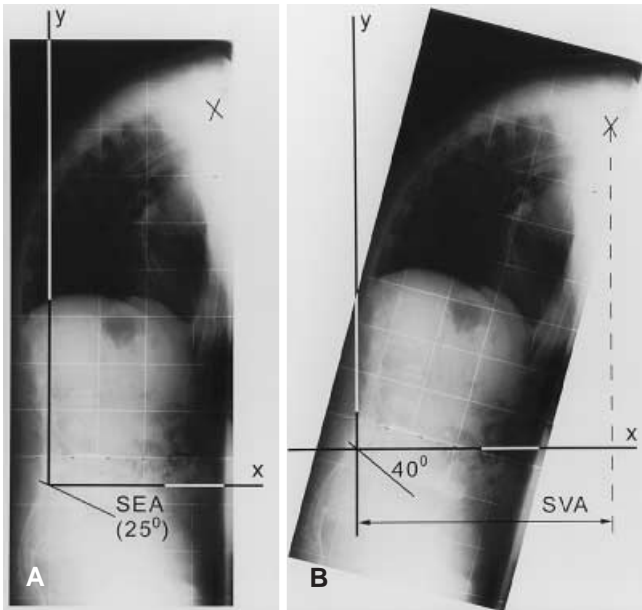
The two basic steps involved in deformity analysis. First, the patient stands relaxed with extended knees and a standard full-length standing lateral radiograph of the whole spine with the center of C7 and SEA is made and digitized. (A) On this radiograph the deviation of SEA from 40° ($40^\circ - \beta = \alpha$) is measured with the grid of the film used as a reference for vertical ($40^\circ - 25^\circ = 15^\circ$, see Fig. 1). Second, the radiograph is projected onto the co-ordinate system with the SEA at 40° (B). The pre-operative SVA is measured by the horizontal distance between the posterior edge of the sacral endplate and the plumb line from C7. The SVA is expressed in millimeters on a scale with a 1-mm division. The osteotomy angle ϕ and the SEA are expressed in degrees, on a scale with a 1° division
